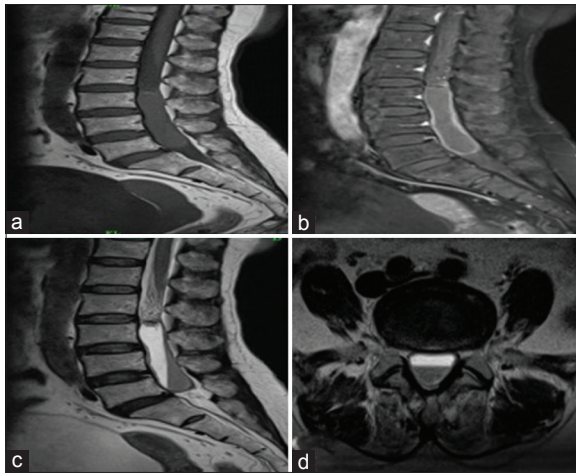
Magnetic resonance imaging L-S spine (Preoperative scans) (a) T1W: Sagittal scan showing a well-defined intradural extramedullary lesion extending from L3 to L5 appearing isointense on T1W. (b): T1W postcontrast: Sagittal scan showing a fluid density lesion at L3–L5 level with peripheral enhancement. (c) T2W: Sagittal scan showing hyperintense lesion and STIR with fluid-fluid level within. (d) T2W: Axial section showing hyperintense lesion
